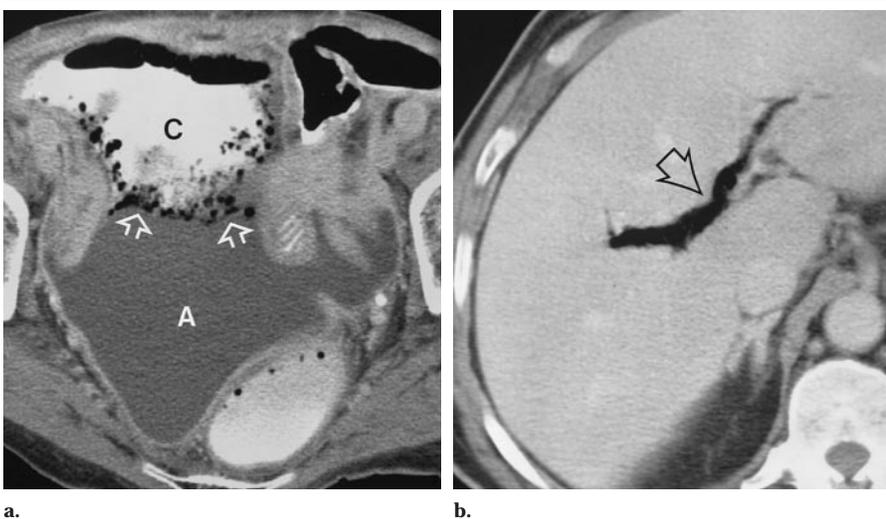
Infarcted right colon in a 72-year-old man with atrial fibrillation who presented with abdominal pain and fever and had an elevated WBC count. (a) Contrast-enhanced CT scan shows pneumatosis affecting the cecum (C) and ascending colon (arrows) and ascites (A) in the pelvis. (b) CT scan shows air in the intrahepatic branches of the portal vein (arrow). At surgery, the right colon was infarcted, and the pelvic fluid was infected.
